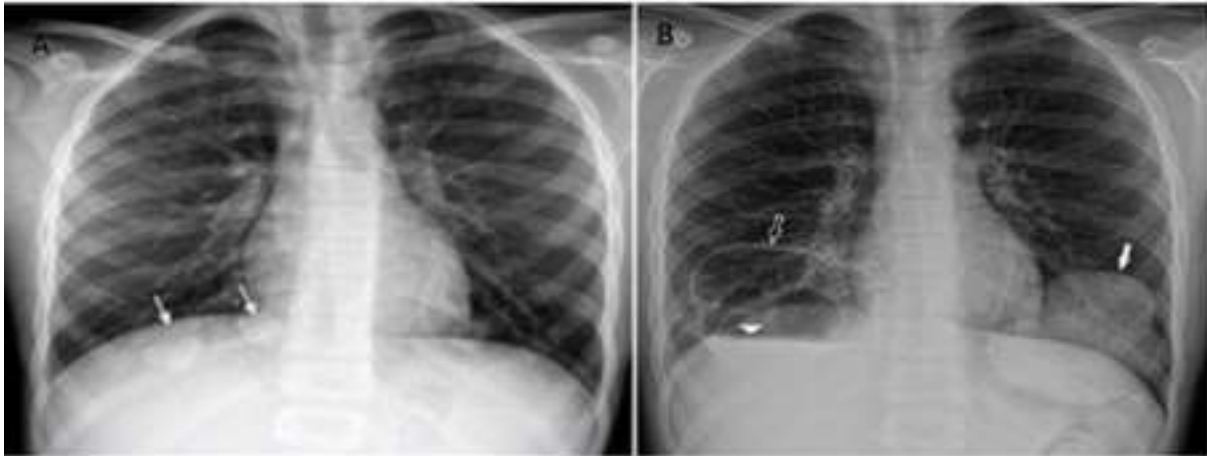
Chest X-ray: Right retro-diaphragmatic nodular lesions at diagnosis (A). Large well-defined thick-walled cystic lesions with an air-fluid level in both lobes in remission (B).
